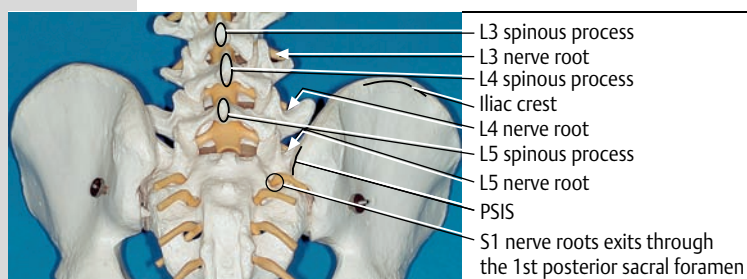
The anteroposterior lumbar spine radiograph is displayed the right way around (right = right) in the field of vision of the practitioner, who assesses and palpates the sitting patient's inferior lumbar region from a posterior direction. Note changes in the anatomical orientation points when scolioses, junctional anomalies, and numeric variations in the number of lumbar vertebrae are present.
